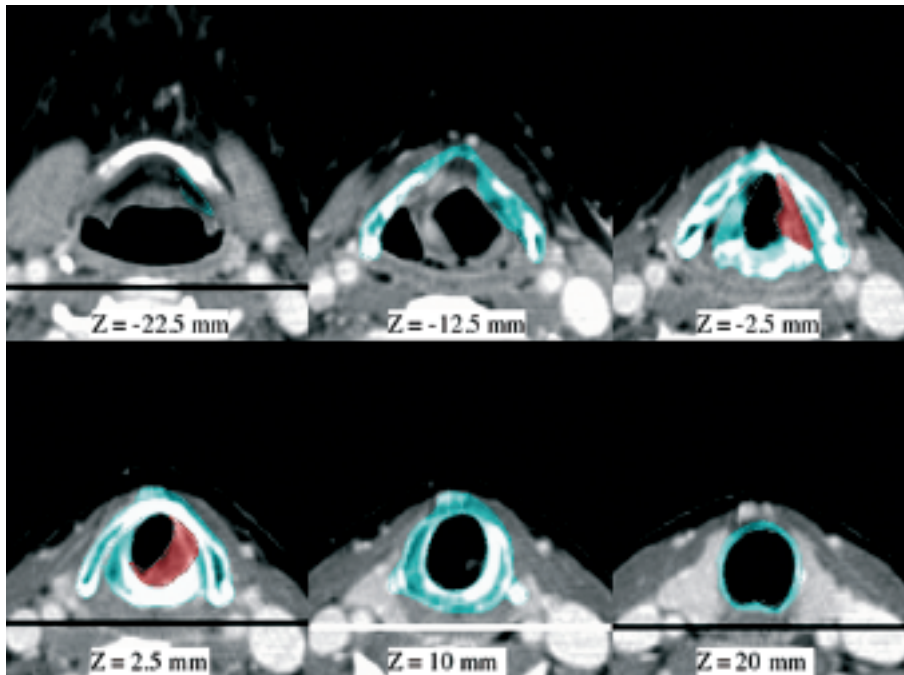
Axial CT slices of a 49y female with a T3 subglottic tumor (GTV in red). Its anterior extension leads to the inclusion of the prelaryngeal fat at the level of the cricothyroid membrane. Its laterality allows to include only the homolateral paraglottic space (CTV in light blue).
